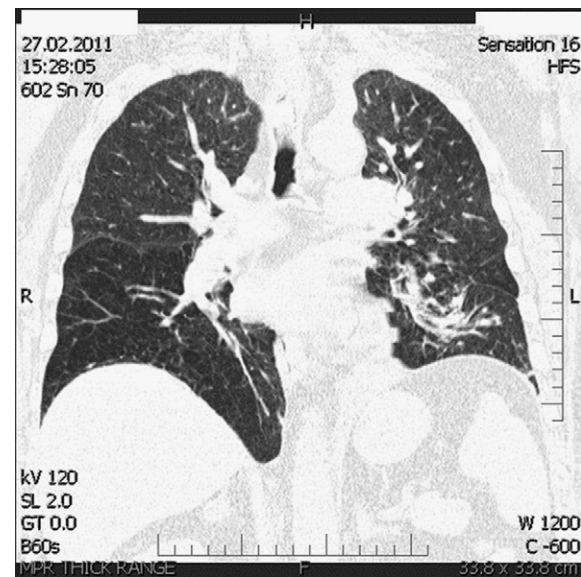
CT day 2 post procedure.
